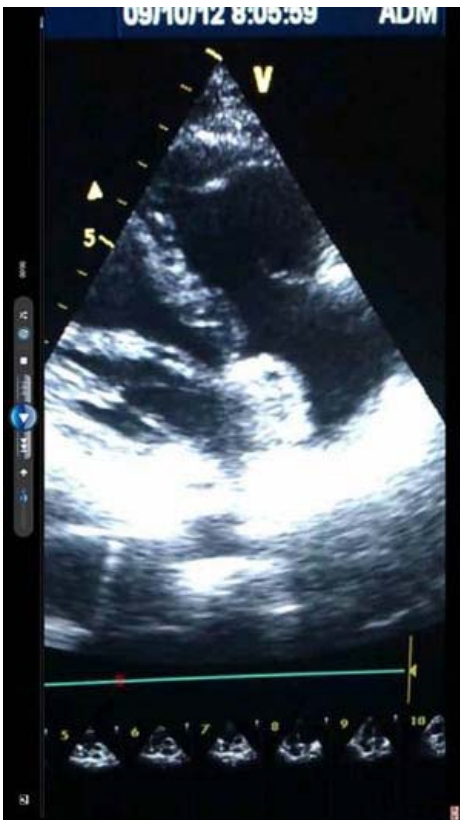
Echocardiography showed a 3.1×1.7 cm cystic mass in the interatrial septum of the right atrium, there was mild-moderate mitral regurgitation.
